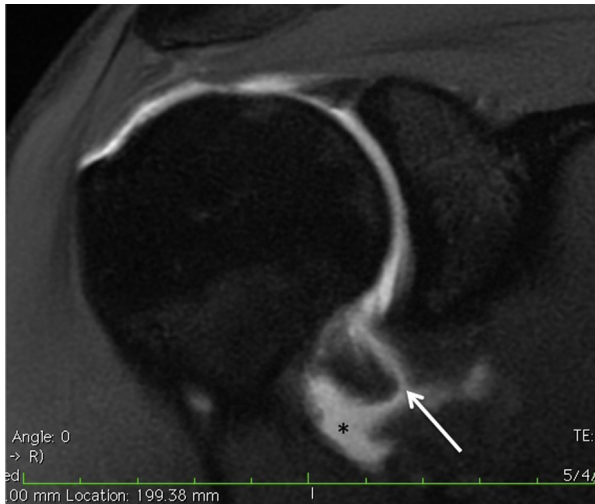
Coronal T2-weighted magnetic resonance arthrogram showing anterior capsular tear (*arrow*) with extracapsular leakage of contrast (*asterisk*).
